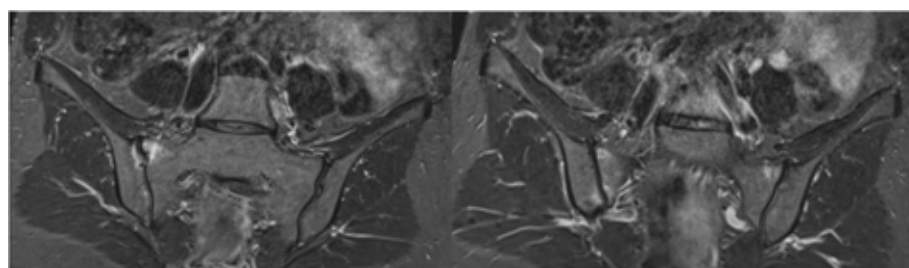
Baseline MRI T2 short tau inversion recovery (STIR) images of sacroiliac bone marrow edema in a 33-year old postpartum woman.
